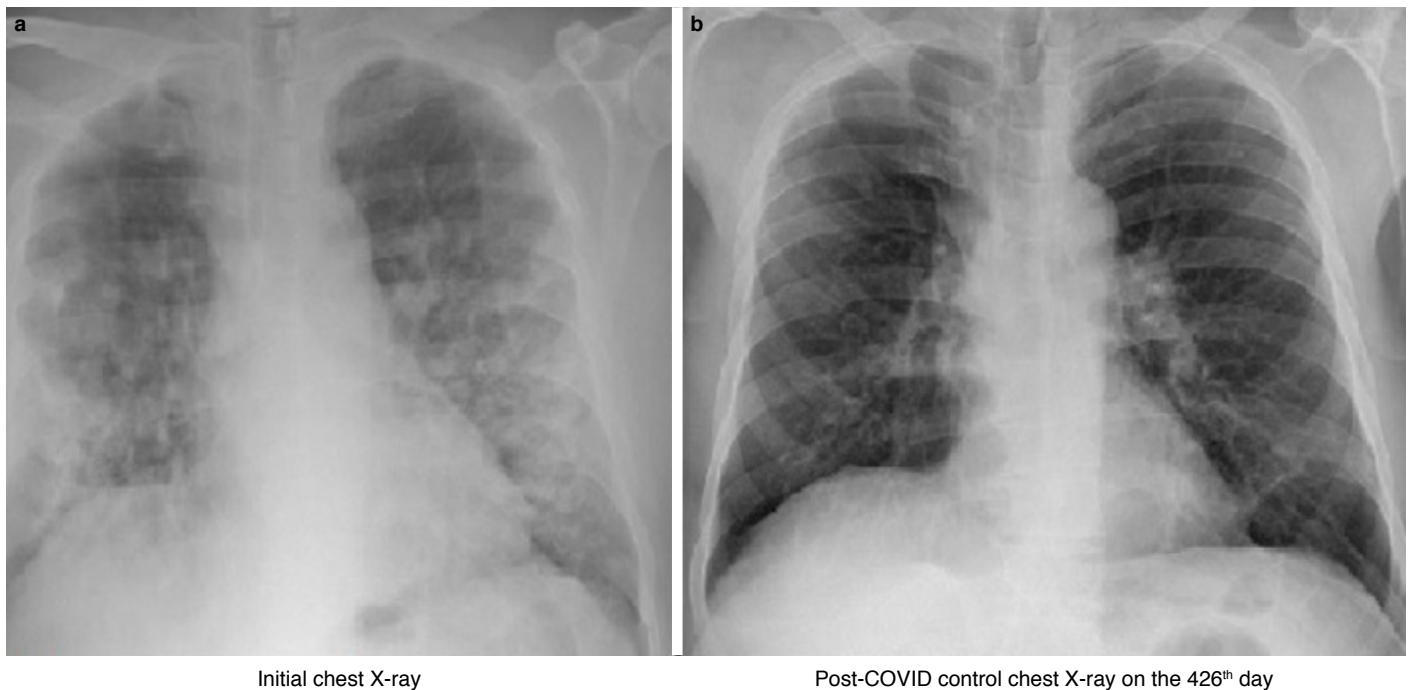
An example of a chest X-ray for a patient without complete regression showing reticular and band-like opacities (a) chest X-ray on the admission to hospital and (b) chest X-ray during the follow-up.
